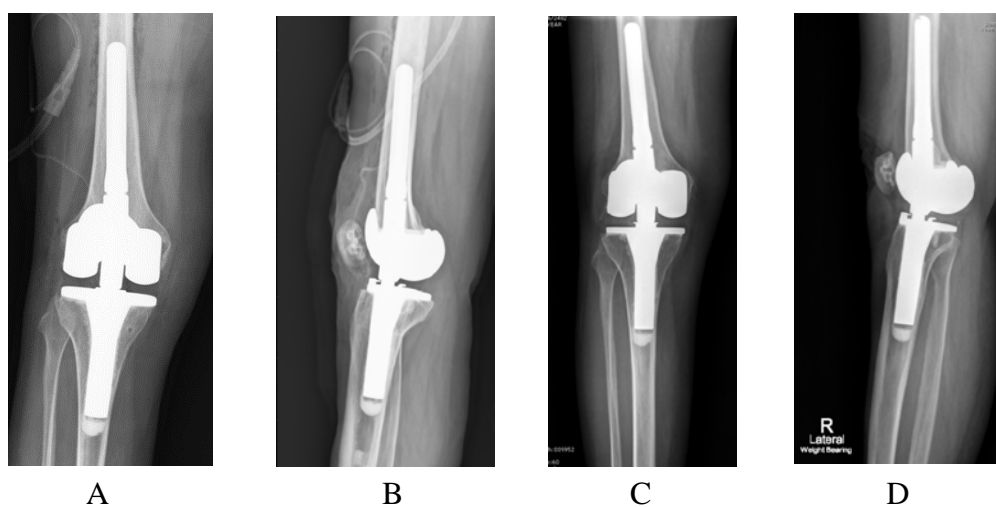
A, B show the immediate post-operative film and C, D were the x-ray at 1 year follow-up. There were neither implant migration nor abnormal radiolucency line between bone-cement and cement-prosthesis interface.
